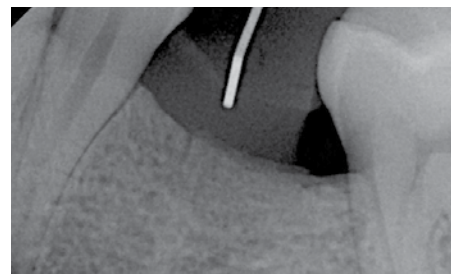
Radiograph depicting the trajectory encroaching on the premolar root.
